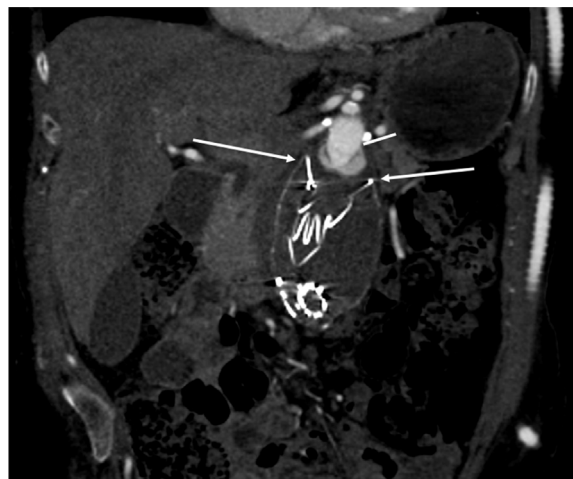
Coronal view computed tomography angiogram of the abdominal aorta at 2.5 years after presentation showing endograft migration with suprarenal struts (*arrows*) >5 mm distal to the lowest renal artery (*white line*). The aneurysm sac measures 6.1 cm, and the aortic neck is 3.6 cm. No endoleak visualized.
